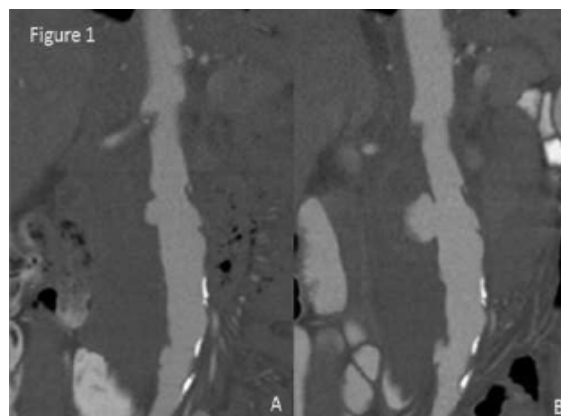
Coronal CT projections demonstrating (A) penetrating aortic ulcer with peri-aortic stranding consistent with infrarenal aortitis, and (B) rapid progression to mycotic aortic aneurysm with contained rupture.
